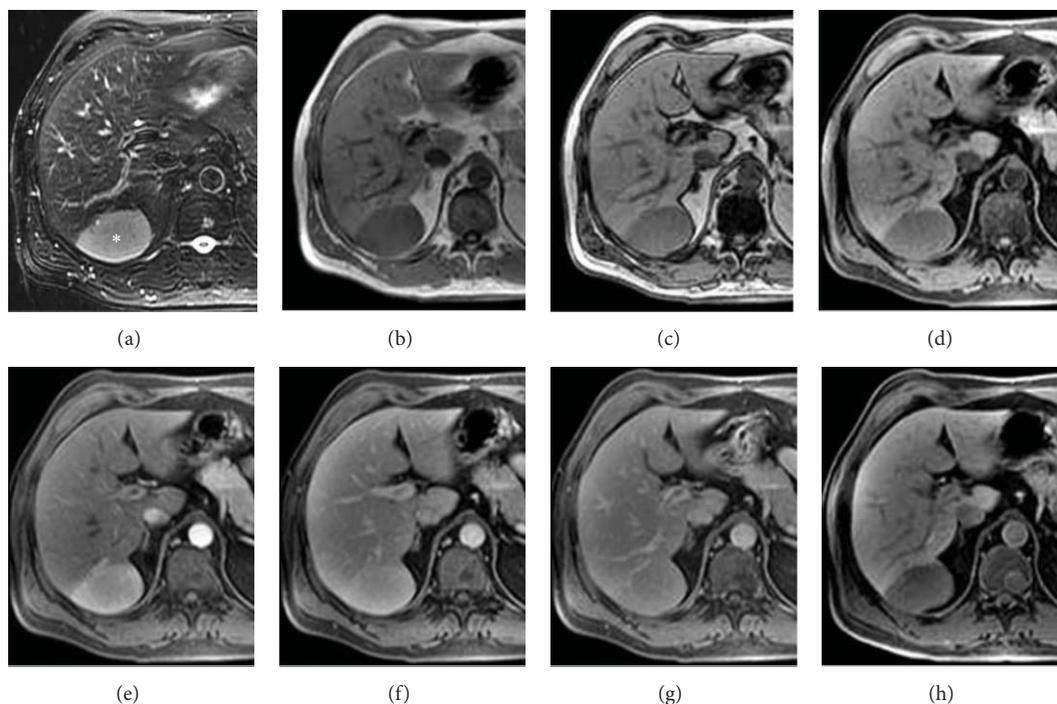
Primary hepatic NH lymphoma. (a) On T2w image well-defined homogeneous moderate hyperintense nodule (asterisk) in S VII. (b-c) T1w in- and out-phased images. The lesion appears homogeneously moderate hypointense on T1w sequences. (d-g) On contrast enhanced MRI the mass shows homogeneous hypervascular enhancement in arterial phase (e) and becomes isointense to liver parenchyma on portal and late dynamic phases. (h) In epatobiliary phase the nodule is homogeneously hypointense.
